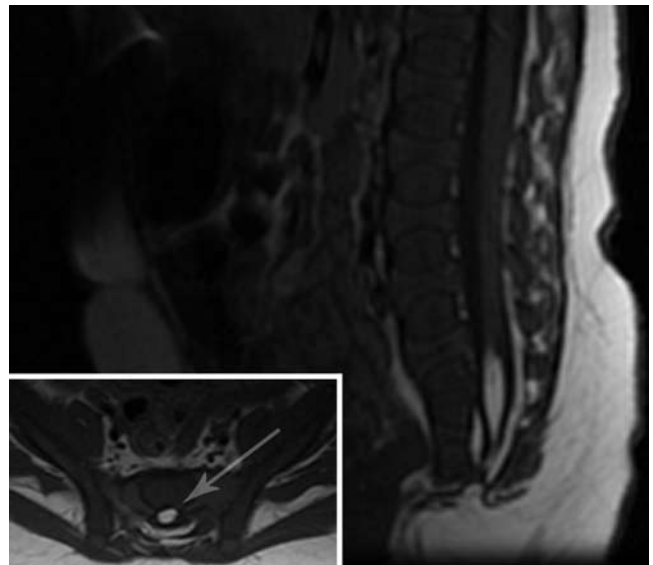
Sagittal T1-weighted MR image acquired in an infant with anal atresia, tracheoesophageal fistula, and vertebral anomalies, showing the conus ending at L-5 in a sizable filum lipoma (arrow in the axial image [inset]). The upper sacral segments are fused while the lower segments are absent.
